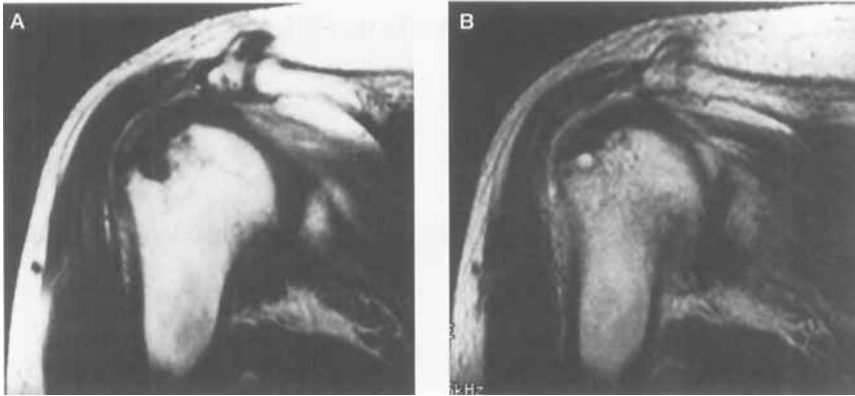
A cystic change in a complete tear of the rotator cuff. Both T1-weighted image (A) and T2-weighted image (B) show a cystic lesion in the middle facet, which corresponds to the location of the tear.
